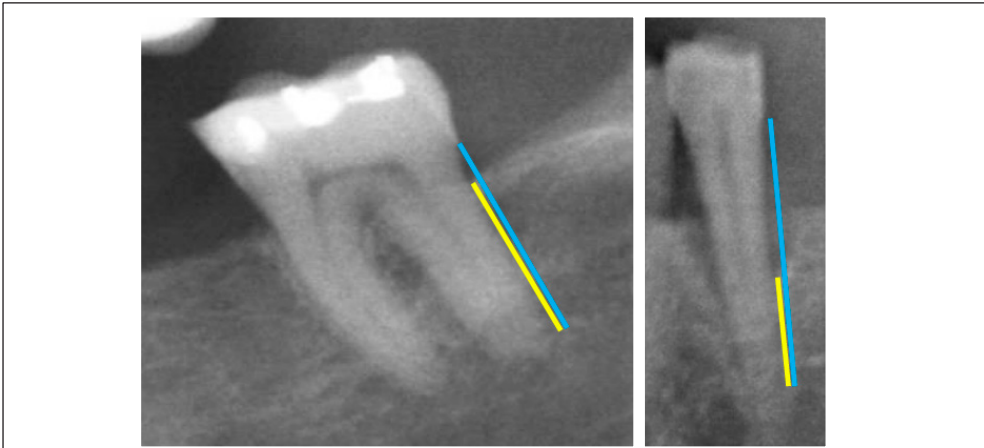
Radiographic measurements from the marginal bone to the tooth apex (yellow line – bone height) and from the cemento enamel junction to the tooth apex (blue line – total root length) for calculating the proportion of remaining bone. Reproduced with permission from Rydén et al, Periodontitis Increases the Risk of a First Myocardial Infarction: A Report From the PAROKRANK Study, *Circulation*. 2016;133:576-83.⁶¹ (Study I)
